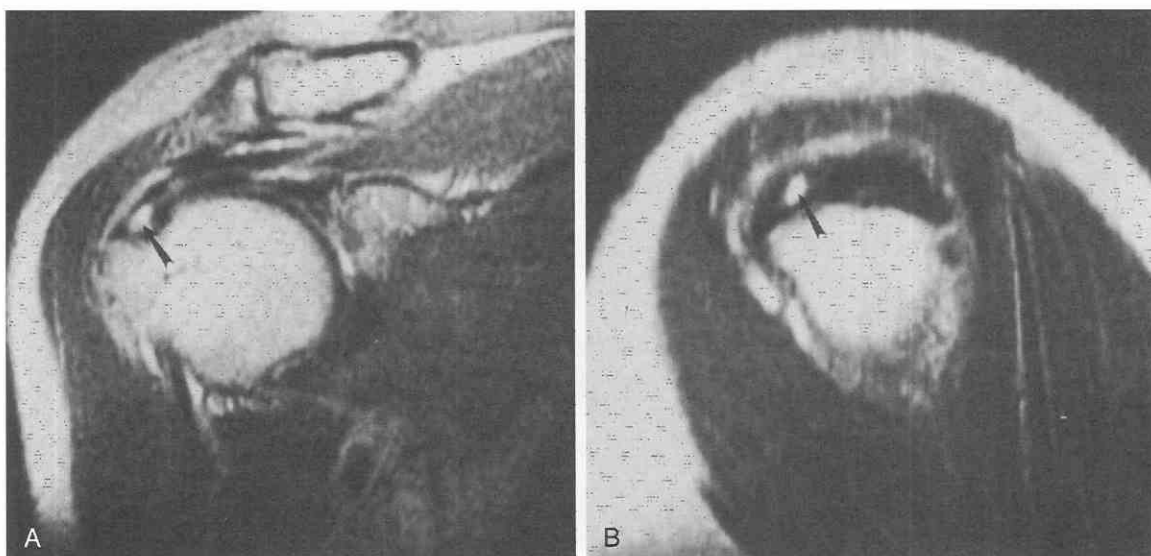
Articular side partial tear. *A*, T2-weighted (TR = 2500 msec, TE = 70 msec) coronal oblique image. *B*, T2-weighted (TR = 2500 msec, TE = 70 msec) sagittal oblique image. On the articular side of the supraspinatus tendon is a bright gap (*arrow*) covered on the bursal side with a thin layer of remaining tendon. Increased joint fluid is present, and some fluid is present in the subdeltoid bursa.
